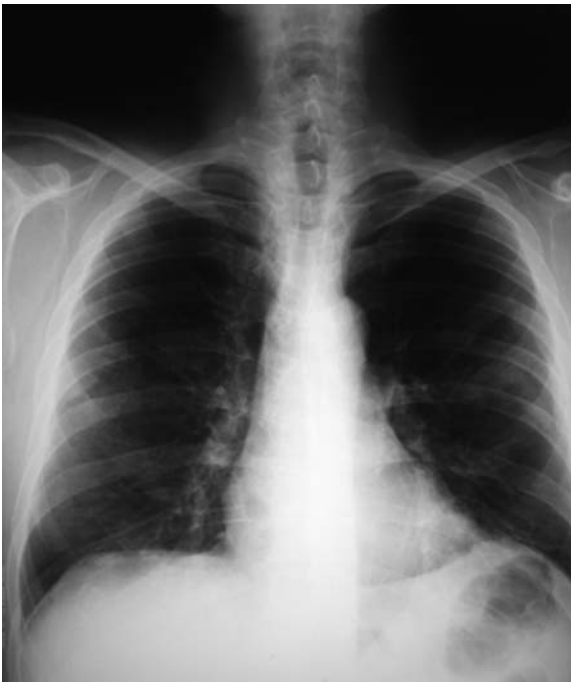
Postero-anterior chest radiograph shows non-calcified pleural plaques appearing as bilateral uneven opacities with clear costophrenic angles
